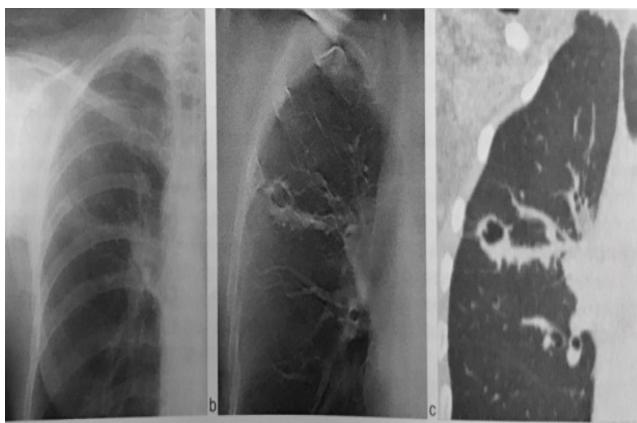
Chest x-ray images
